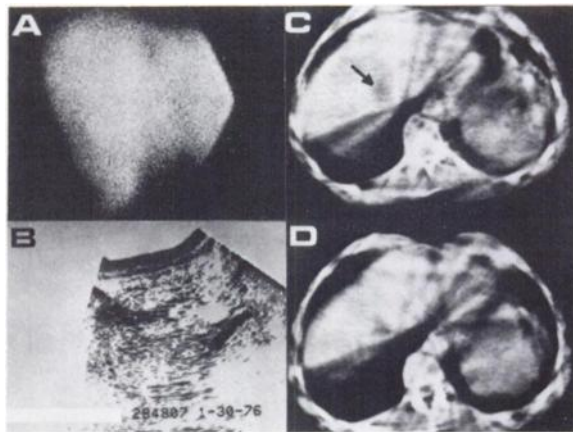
(A) Anterior gamma image: focus of decreased activity in superomedial portion of right lobe. Lesion or hepatic vein? (B) Longitudinal sonogram (head to viewer's right): focus seen in (A) is sonolucent. (C, D) CT without and with contrast material: clearly identified lucency (arrow) fails to opacify. Hepatic vein and other vascular structures are excluded. Diagnosis of simple hepatic cyst was made.
